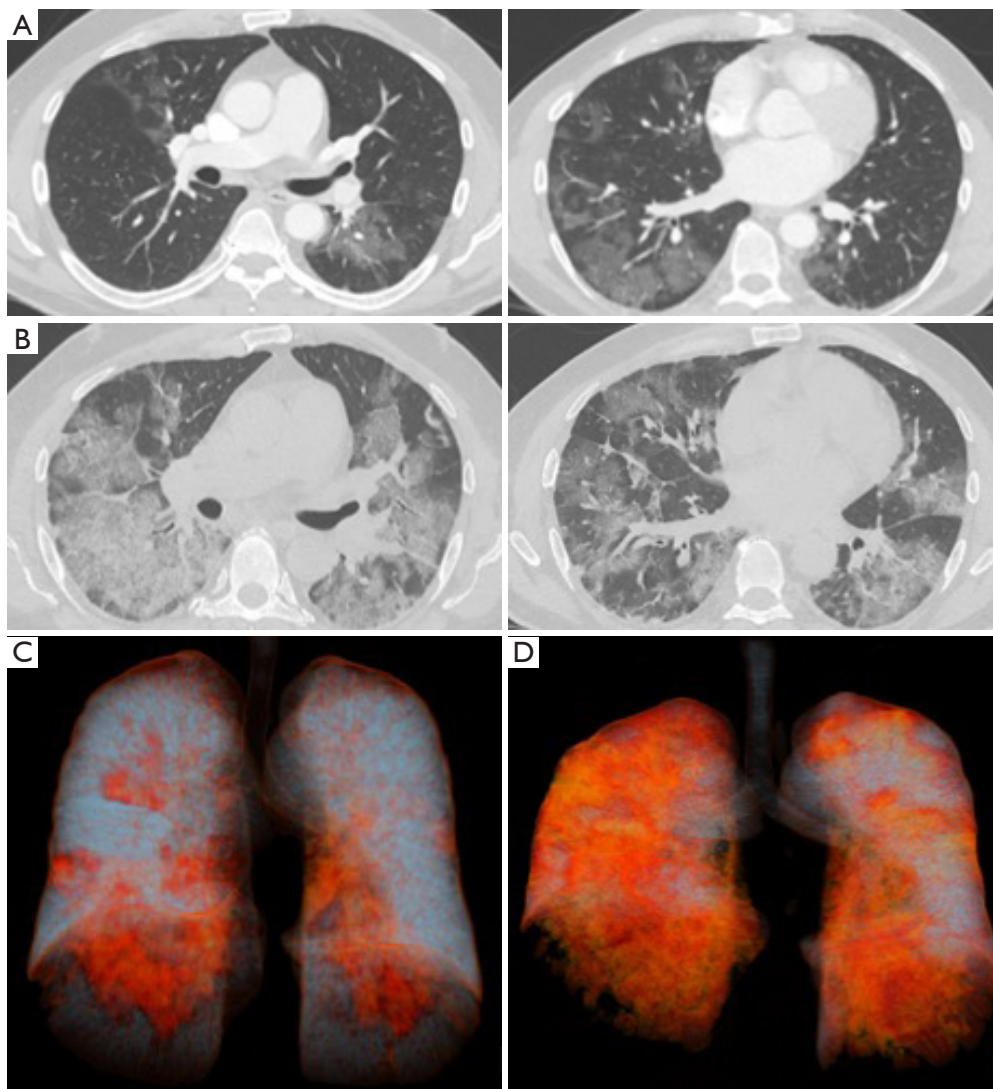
CT-Thorax findings and 3D Volume rendering show a typical COVID-19 infection with increasing involvement of pulmonary parenchyma during hospital stay. (A) CT Thorax at hospital admission with patchy peripheral and peribronchovascular ground glass opacities displayed here in two sectional images. (B) CT Thorax 5 days after hospital admission. Compared to the initial CT, the involved parenchyma increased, the preexisting ground glass opacities got denser, new interlobular septal thickening is seen and a typical crazy paving pattern developed. Also new subpleural consolidations are seen. (C) 3-D Volume rendering visualizing the involved parenchyma in orange at hospital admission. (CT severity score 7/20). (D) 3-D Volume rendering visualizing the progressing involvement of lung parenchyma 5 days after hospital admission. (CT severity score 14/20). COVID-19, coronavirus disease 2019.
